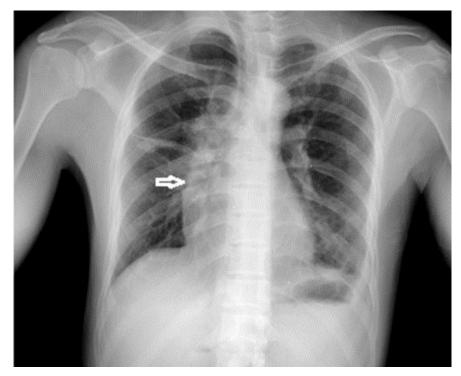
Chest radiograph showing thickening and reduction of the right mediastinum after treatment.
